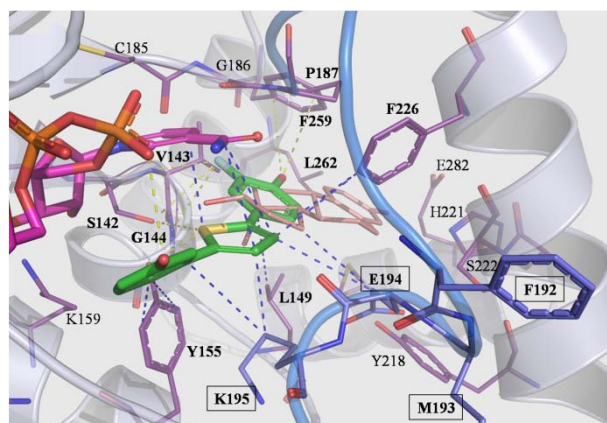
Docking complex between 17 β -HSD1 (X-ray 1FDT-A) and compound 23 (green; alternative binding mode). NADPH, interacting residues and ribbon rendered tertiary structure of the active site are shown. Residues of the flexible loop are rendered in sticks and colored in blue. Hydrogen bonds and π - π stackings (and hydrophobic interactions) are drawn in yellow and blue dashed lines, respectively. For comparison, E2 is depicted in magenta lines.
